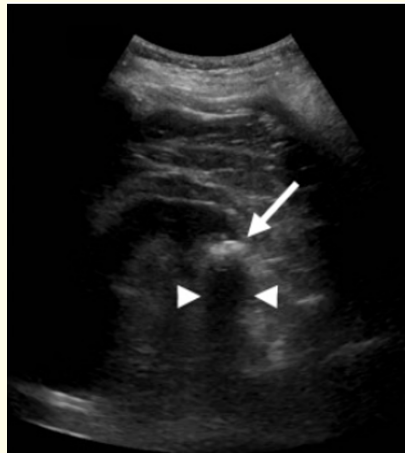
Ultrasound of kidney suggestive of kidney stone [11].
